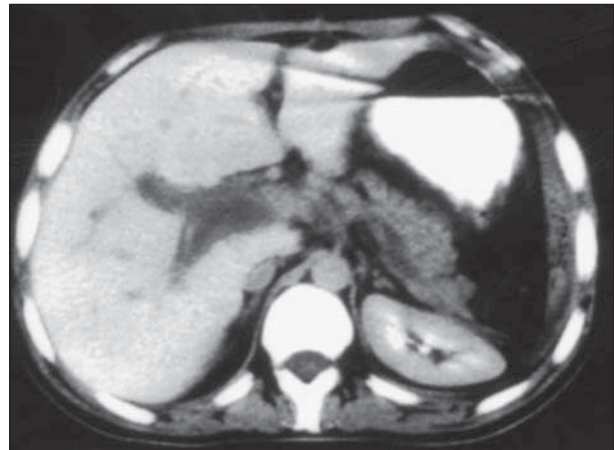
Computed tomographic scan of a case of postsplenectomy portal vein thrombosis. The clot expands intrahepatically and to the superior mesenteric vein. The patient presented with ileus, abdominal pain, and fever. The vessel was recanalized in 2 months.
